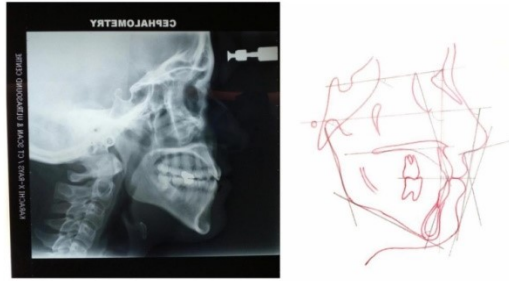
Post-treatment cephalometric radiograph and its tracing and orthopantomogram
